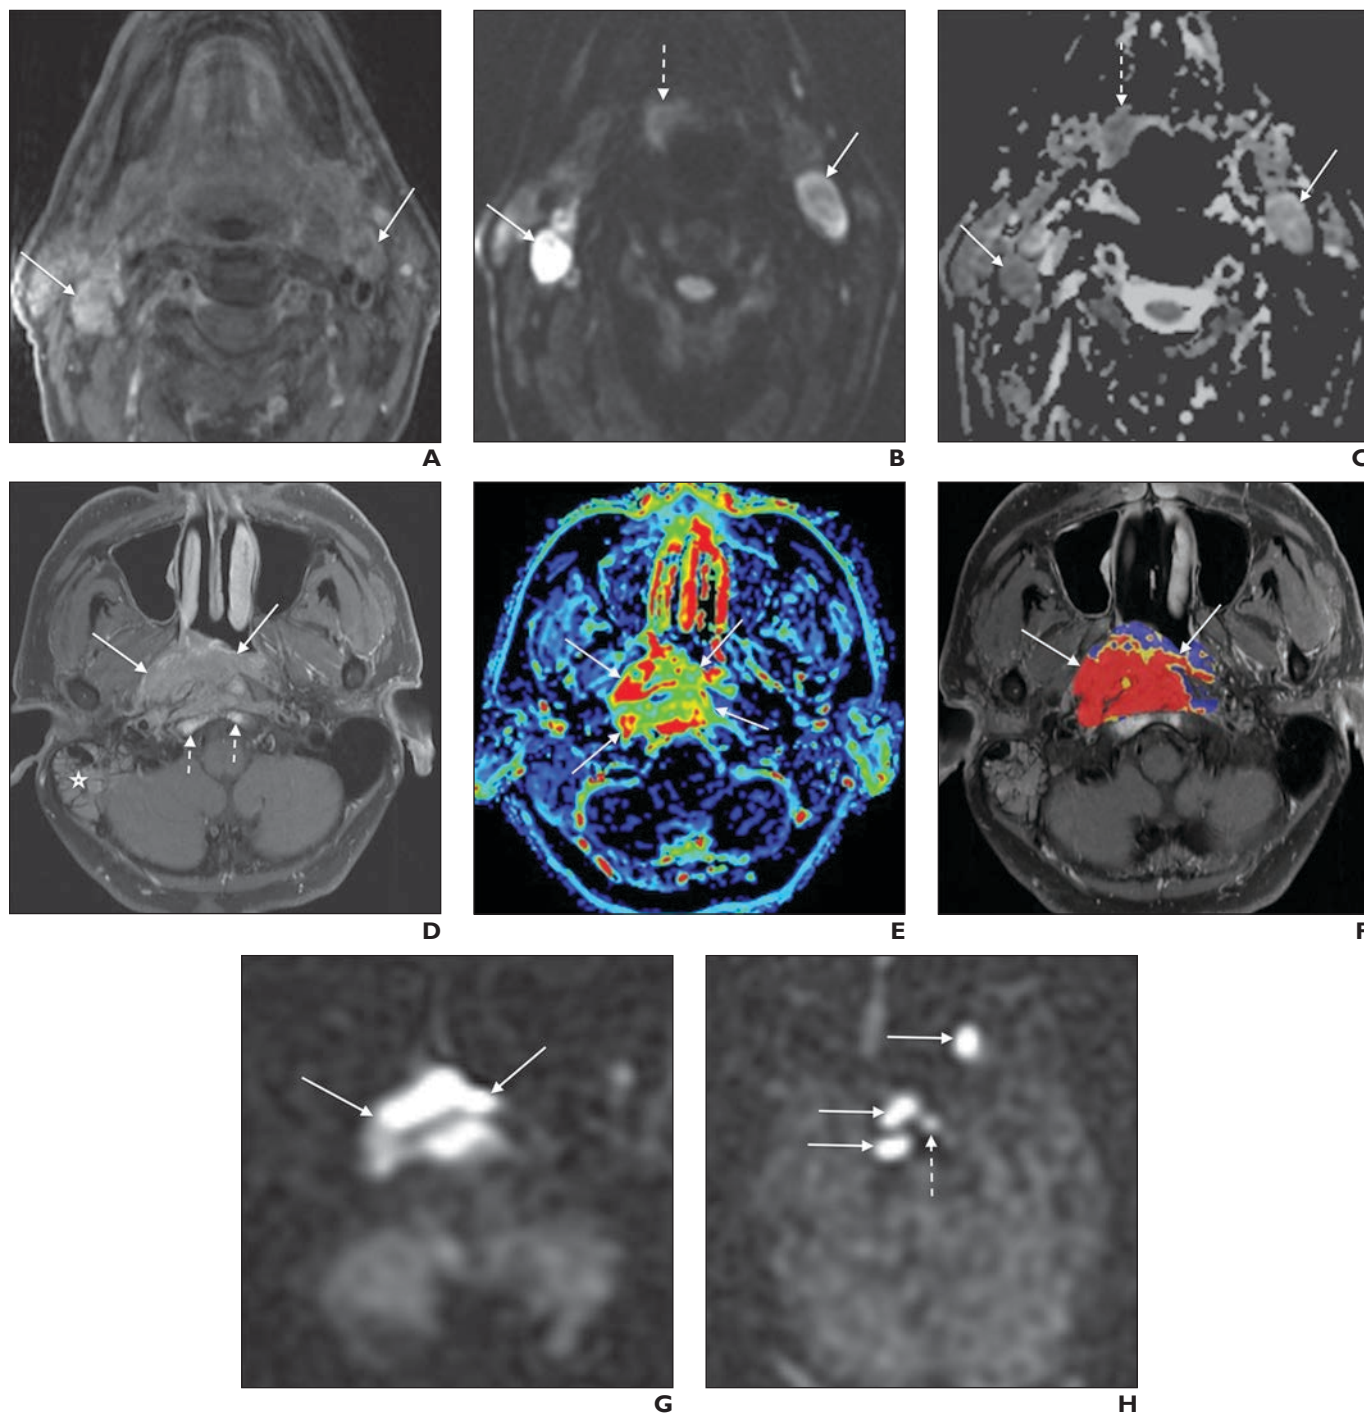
Advanced head and neck MRI sequences.
